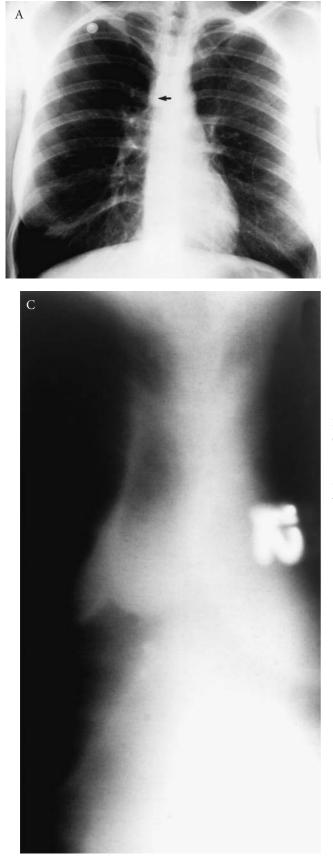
Radiologic definition of adenoid cystic carcinoma in a 28-year-old woman. A, Standard posteroanterior view shows little obviously abnormal. The arrow indicates tumor in the lower trachea. B, Large lower tracheal mass is seen near the carina on a lateral roentgenogram. C, Anteroposterior tomogram outlines the supracarinal mass.
